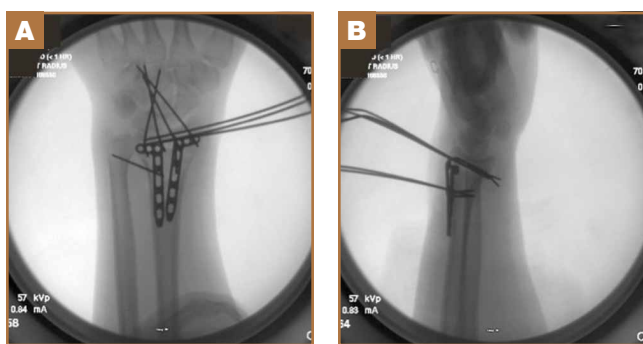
(A) Anteroposterior and (B) lateral radiographs show placement of lateral and intermediate column plates while reduction is being held. Kirschner wires are placed distal enough to allow placement of plates while assistant holds reduction.
